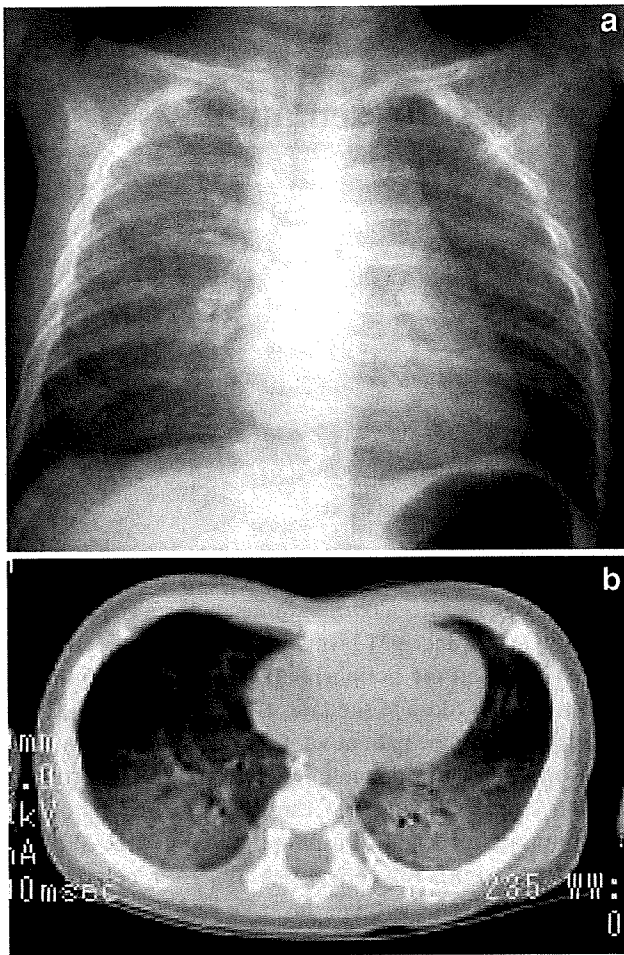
Radiological findings in the patient. a Chest radiograph demonstrated bilateral perihilar opacities. b Computed tomography demonstrated diffuse ground-glass opacities in both lungs
